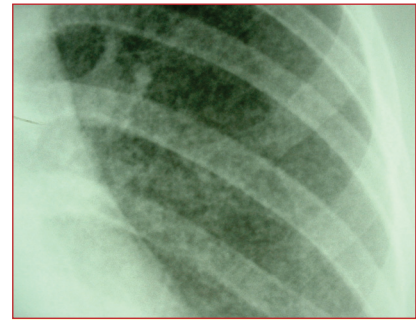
Chest radiograph appearance of miliary TB.
